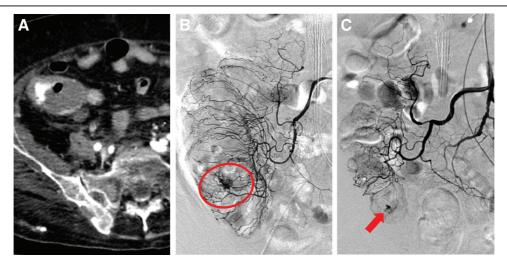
A 74-y-old ESRD female patient with bloody stool for multiple days. A, Multidetector computed tomography showed contrast extravasation in the ascending colon. B, Superior mesenteric artery (SMA) angiogram confirmed active bleeding in the ascending colon (circle). Vasospasm therapy was performed. C, SMA angiograms showed recurrent bleeding at the cecum (arrow) 4 d after. No rebleeding after the second vasospasm therapy.
